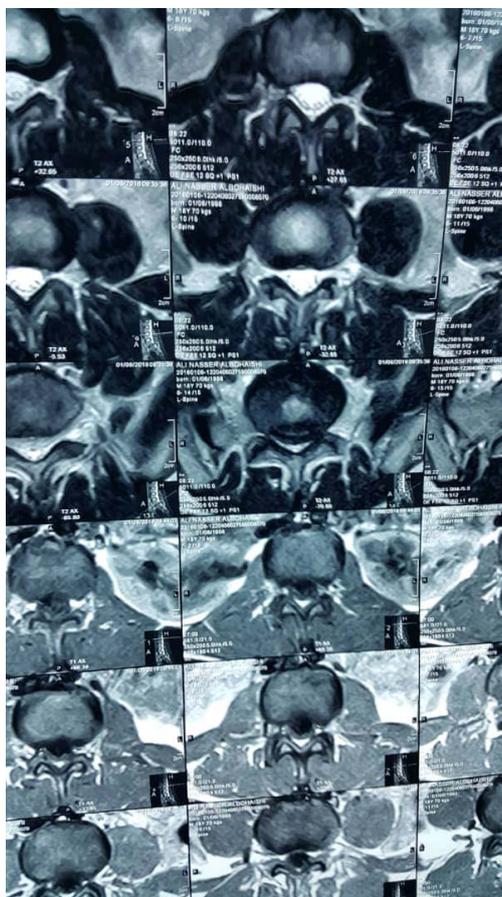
MRI lumbar spine, axial view of male patient 16 years old with L5/S1 disc herniation.
